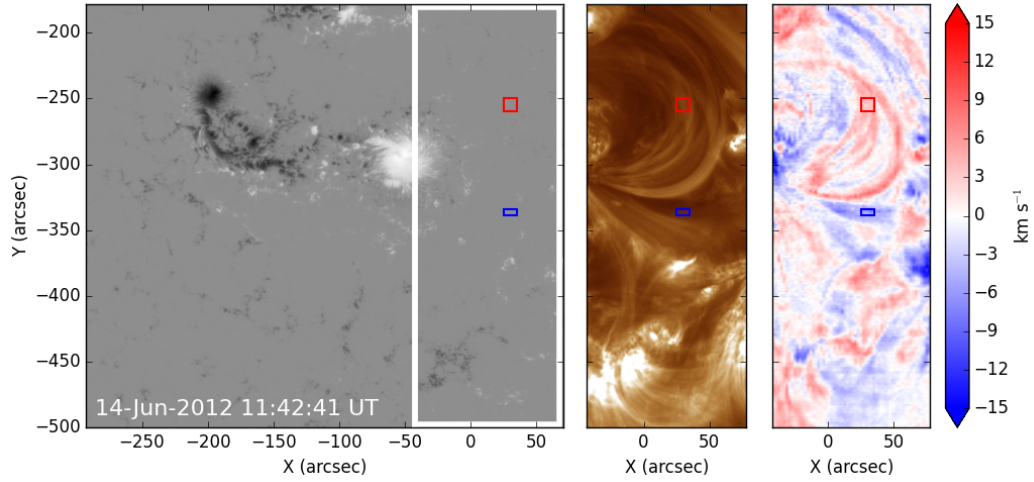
HMI line-of-sight magnetogram (left), 193 Å AIA image (middle) and an EIS Doppler-velocity image produced at 195.12 Å (Fe XII, right). The AIA and EIS images show an area to the west of the positive sunspot, and this field-of-view is marked on the HMI image. Downflows (red) are observed by EIS in loops that extend to the north-west of the positive sunspot and upflows (blue) are observed to the south-west of the sunspot. The composition analysis is performed on these flow areas in locations shown by red and blue boxes. Since these EIS images are produced via a raster that began at 11:42 UT, the red and blue boxes sample plasma that is observed at $\approx 12:00$ UT. Doppler velocities are saturated to $\pm 15 \text{ km s}^{-1}$.
